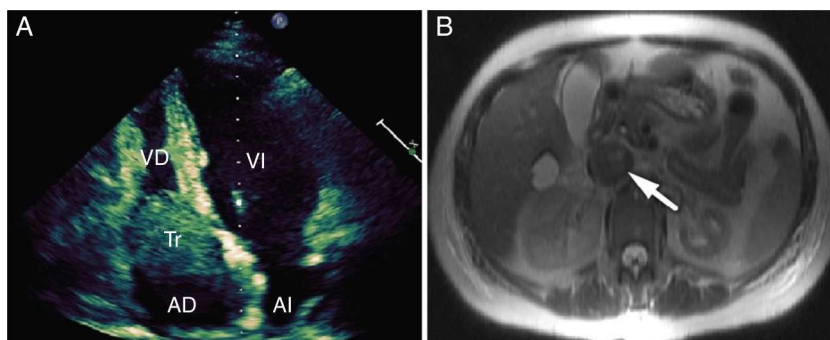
(A) Transthoracic four-chamber ultrasound, apical view, showing large thrombus in the right atrium shifting toward the right ventricle during diastole. AD, right atrium; AI, left atrium; Tr, thrombus; VD, right ventricle; VI, left ventricle. (B) Abdominal magnetic resonance image of inferior vena cava thrombosis.
